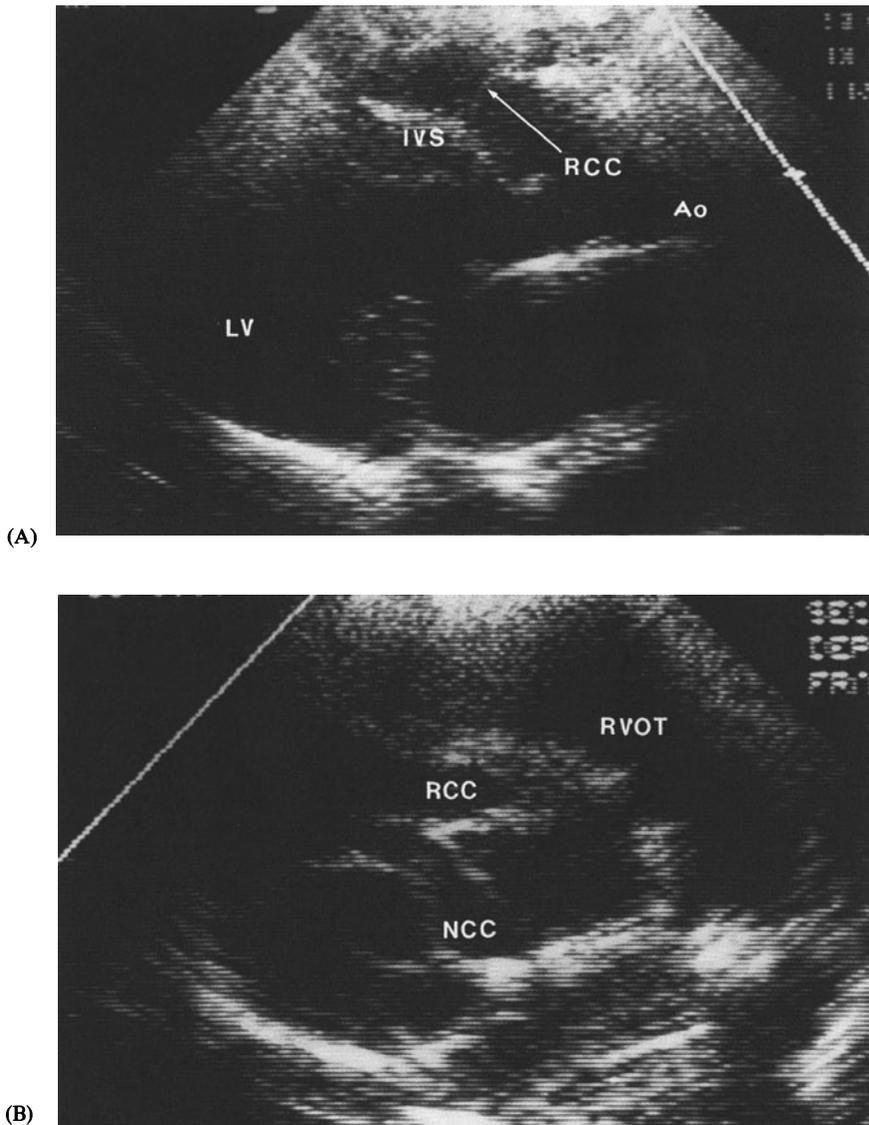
(A) Parasternal long-axis view demonstrating prolapse of the RCC in a patient with VSD. (B) Parasternal short-axis view showing deformity of the RCC and NCC in relationship to a perimembranous VSD. (Ao, aorta; LV, left ventricle; IVS, interventricular septum; RVOT, right ventricular outflow tract; RCC, right coronary cusp; LCC, left coronary cusp.)
